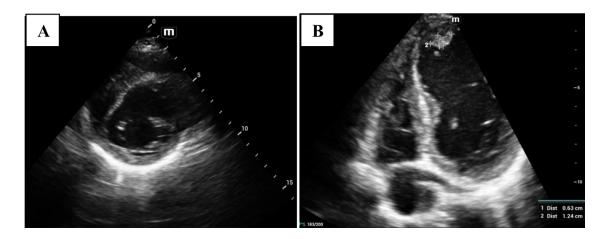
Panel A: Echo: parasternal short axis of the left ventricle with mild aneurysm. Panel B: apical 4 chamber view with apical thrombus of 0.63 x 1.24 cm.
